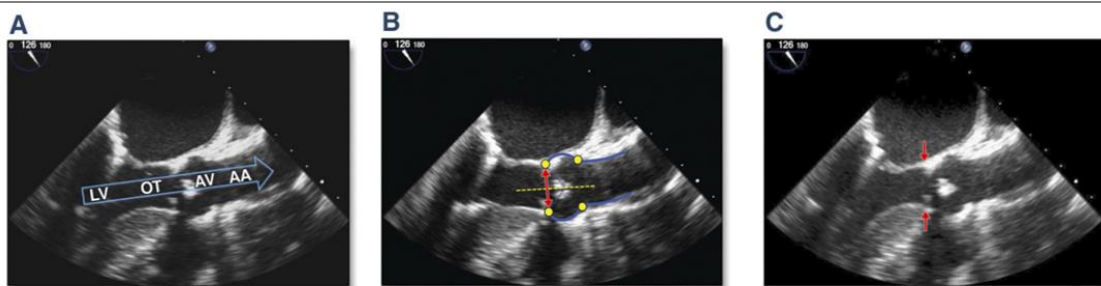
Aortic Annular View With Transoesophageal Echocardiography. Midesophageal long-axis zoomed-up view (“3-chamber view”) during the early systolic phase of the cardiac cycle (A). The left ventricular chamber (LV), the outflow tract (OT), the aortic valve (AV), and the ascending aorta (AA) are aligned. An orthogonal plane is considered as a reference (B, dotted yellow line). The four edges of the aortic sinus (yellow points) are the landmarks: the sinotubular junction defines the upper reference plane, and the insertion point of the aortic valve leaflets on the outflow tract defines the lower reference plane. The aortic valve annulus is measured as the distance between the hinge point of the right cusp and the edge of the sinus at the side of the commissures between the left and non-coronary cusps, including calcifications (red line with arrowheads) (C). [26]
